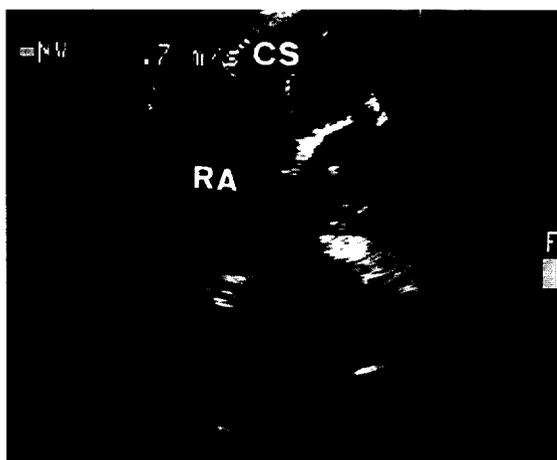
Modified transesophageal four-chamber view visualizing the coronary sinus (CS) draining into the right atrium (RA) with the Doppler sample volume in the position used for measurements.
